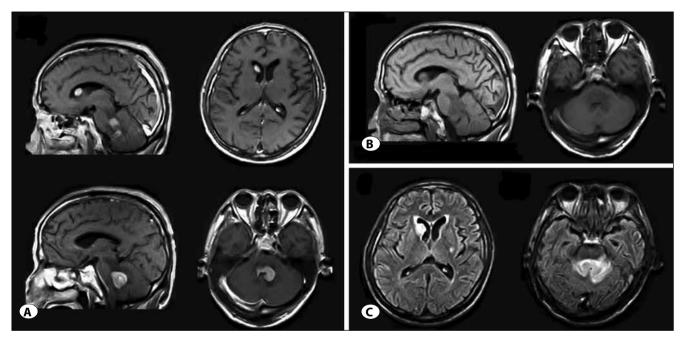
A) Sagittal (left) and axial (right) T1-weighted contrast MRI showed two well-demarcated, enhanced lesions, one in the right lateral ventricle and another in the fourth ventricle. B) The lesions are hypointense on T1-weighted MRI (left: sagittal, right: axial) and C) hyperintense on FLAIR-weighted MRI.
